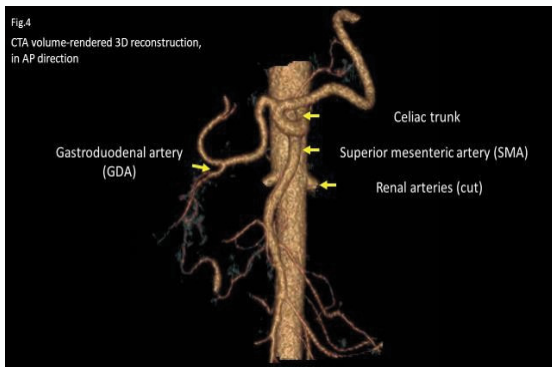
CTA volume rendered 3D reconstruction, in AP direction.
